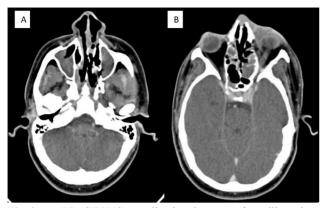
CT PNS revealing involvement of maxillary sinus (L>R) with obliteration and widening of bilateral maxillary ostia and infundibulum. B) Involvement of left maxillonasal region with extension to the orbital cavity s/o left orbital cellulitis.
